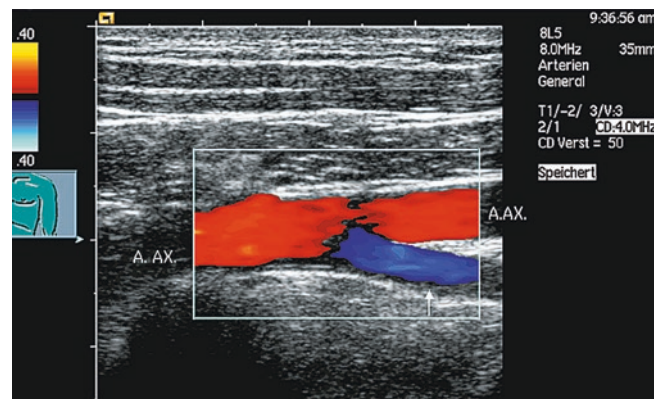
Directional artifact (color Doppler). The axillary artery (infraclavicular) (A.AX.) with a branch for the musculature/chest wall. Blood flowing towards the ultrasound probe is coded red; blood flowing away from the probe is coded blue (see color scale). The branching artery (arrow) is blue, the change of color from red to blue occurs via black. Thus, here (at a 90° Doppler angle to the ultrasound probe), there is no blood flow relative to the ultrasound probe
